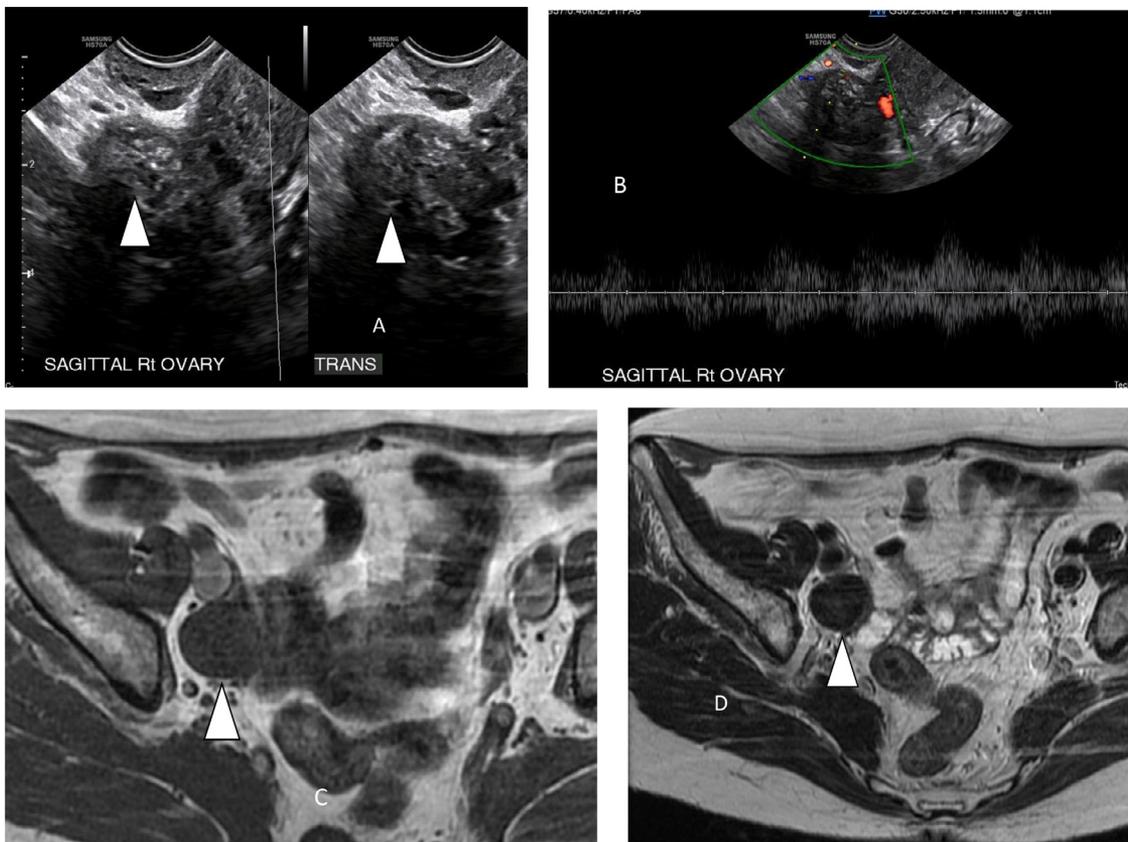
Solid ovarian tumor. Ultrasound image demonstrates a solid tumor of the ovary with a heterogenous echotexture and focal hyperechogenicities (A). Color Doppler score of 1 within the tumor. Flow was observed within surrounding ovarian tissue (B). Axial T1-weighted image demonstrates a round solid mass of intermediate to low signal intensity (arrow-head in C) and T2-weighted axial image shows low signal (arrow-head in D). Surgical diagnosis was Brenner's tumor of the ovary.
